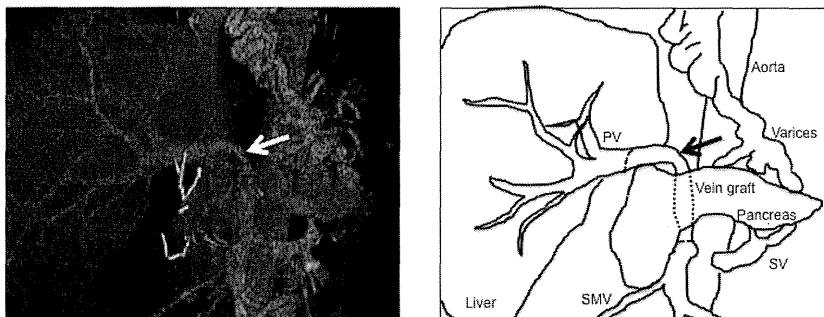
A graft using the recipient's left internal jugular vein was placed in an end-to-end fashion with the superior mesenteric vein proximal to the thrombosis through pancreatic dorsum after ligation the inferior mesenteric vein, the inferior pancreaticoduodenal vein, and the splenic vein. Postre-transplant enhanced computed tomography revealed patency of the vein graft (arrow).
